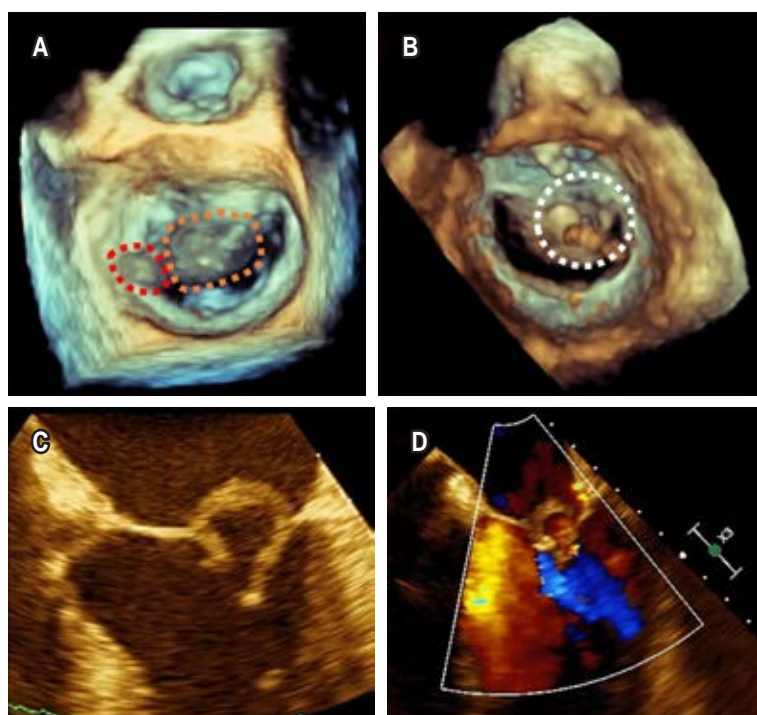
Transesophageal echocardiography: A) 3D view from the left atrium demonstrating an 11 × 5 mm vegetation on the P1 annulus of the mitral valve (red dotted line mark) and an anterior mitral leaflet perforated aneurysm (orange dotted line mark), B) 3D zoom-mode acquisition of mitral valve in mid-diastole from a ventricular perspective with discontinuity of the anterior mitral leaflet at segment A2 (white dotted line mark), C) 2D image at 30° showing an abnormal ring-like structure on anterior mitral leaflet compatible with a perforated aneurysm, D) 2D image with color Doppler showed mitral regurgitation and turbulent flow inside the saccular like image.
